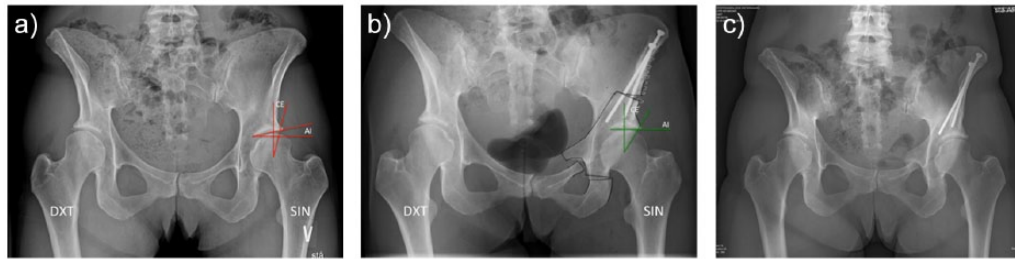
a) Pre-operative and post-operative radiographs of a female patient. The pre-operative CE-angle was 17° on the left side and 12° on the right side. The pre-operative acetabular index angle was 19° on the left side and 11° on the right side. b) Post-operatively, the CE-angle is 30° and the AI-angle is 0° . The goal of correction is an AI-angle close to 0° . An AI-angle $< 0^\circ$ will cause impingement. c) One year post-operatively the osteotomies are healed.
